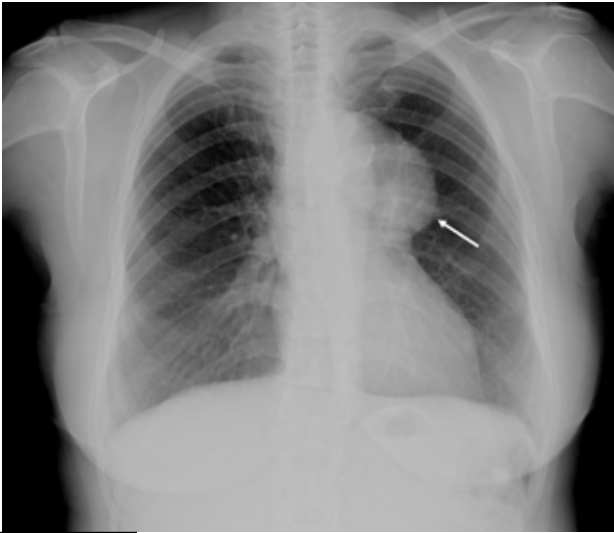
Chest radiography – There is a large mediastinal mass at the level of the aorto-pulmonary window (arrow). Lung parenchyma does not show any abnormalities.*
